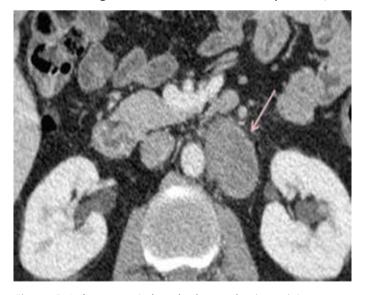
Left paraaortic lymphadenopathy (arrow) is seen on axial computed tomography image
